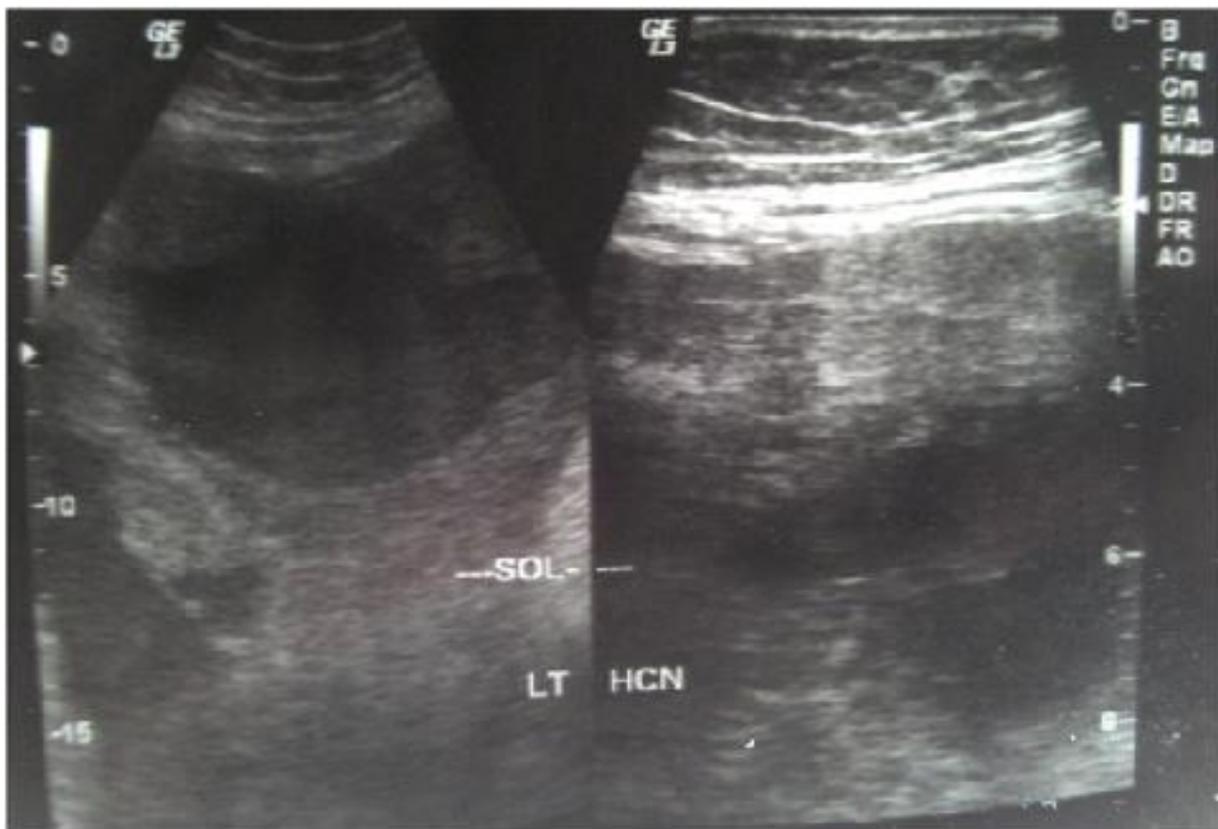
Ultrasonography of the whole abdomen showed huge heterogenous space occupying the left hypochondrium
